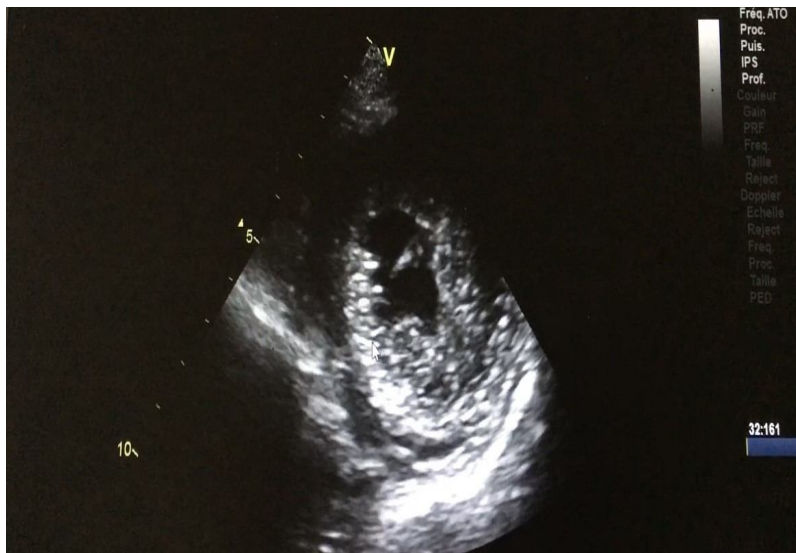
Parasternal short-axis echocardiographic section showing an aspect of non-compacted tissue at the apical level with a ratio of compacted to non-compacted tissue of 3.14
